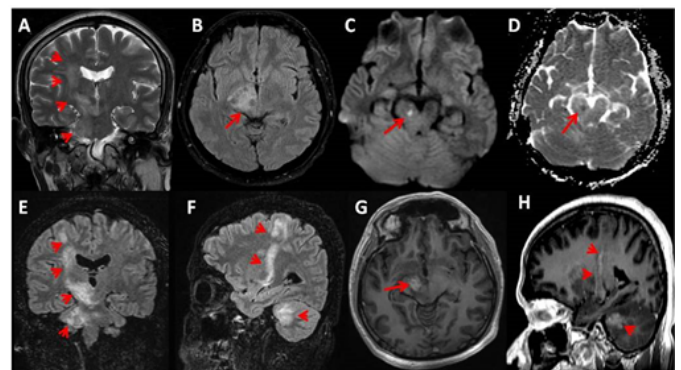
(4A) T2 weighted coronal section of the brain shows hyperintensity along the right corticospinal tract (short arrows). (4B) FLAIR axial image of the brain shows bulky and hyperintense right cerebral peduncle (arrow). (4C & 4D) DWI and ADC images axial section through the brain show patchy areas of restricted diffusion in right cerebral peduncle (arrows). (4E & 4F) Coronal and Sagittal FLAIR images through the brain show hyperintensity along the right corticospinal tract and middle cerebellar peduncle (short arrows) respectively depicting tunnel sign. (4G & 4H) Post-contrast T1 weighted axial and sagittal images show enhancing foci in the right cerebral peduncle (arrow) and track-like enhancement along the corticospinal tract (short arrows) respectively.
